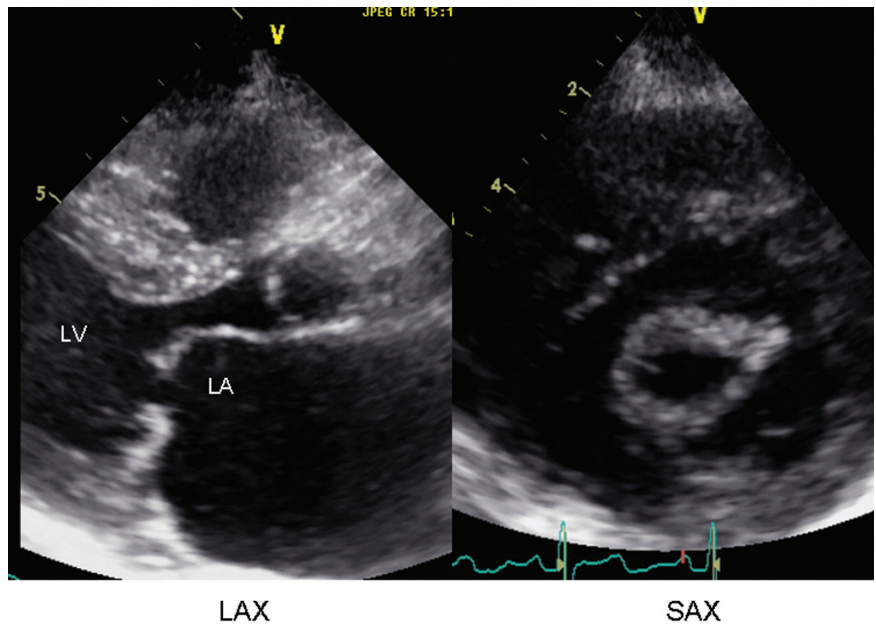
Echocardiographic analysis of mitral stenosis. Transthoracic echocardiography. Parasternal long-axis (left) and short-axis (right) views showing MS. Note on the short-axis view the bilateral commissural fusion without calcification. LA, left atrium; LAX, long-axis view; LV, left ventricle; SAX, short-axis view. Courtesy of Dr E. Brochet.
